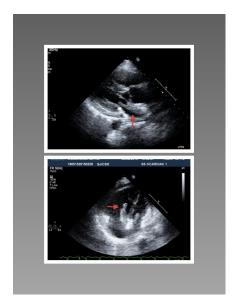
Apical 4 chamber view showing a sessile mass attached to interatrial septum on RA and LA side; parasternal long axis (plax) view showing LA myxoma protruding into LV cavity
